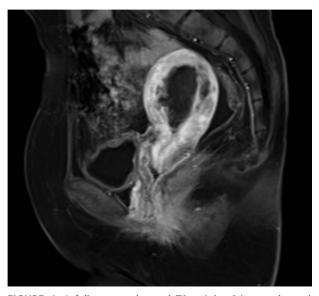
A follow-up enhanced T1-weighted image showed decreased thickness of the uterine wall after 3 circles of chemotherapy.
